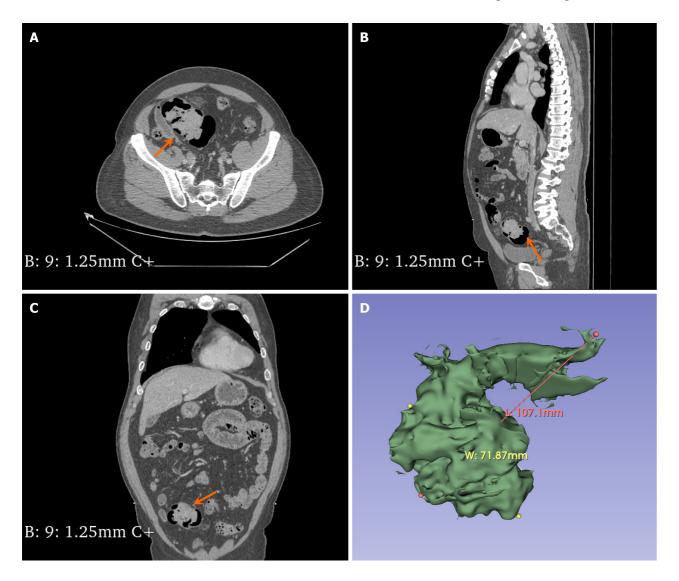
Contrast-enhanced computed tomography of the abdomen. A: The sigmoid colon mass was observed in the horizontal plane; B: The sigmoid colon mass was observed in the sagittal planes; C: The sigmoid colon mass was observed in the coronal planes; D: 3D reconstruction model of sigmoid colon mass. The orange arrow points to the sigmoid mass.
